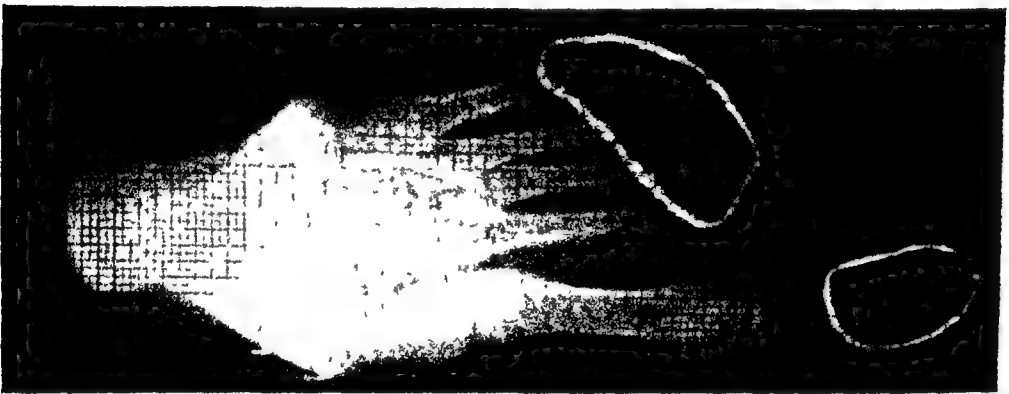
ORTHODYNAMIC RADIOGRAPH (X-RAY PAPER) Mildly inverted foot excessive imprint to lateral metatarsophalangeal joints and the interphalangeal distal area of the great toe
